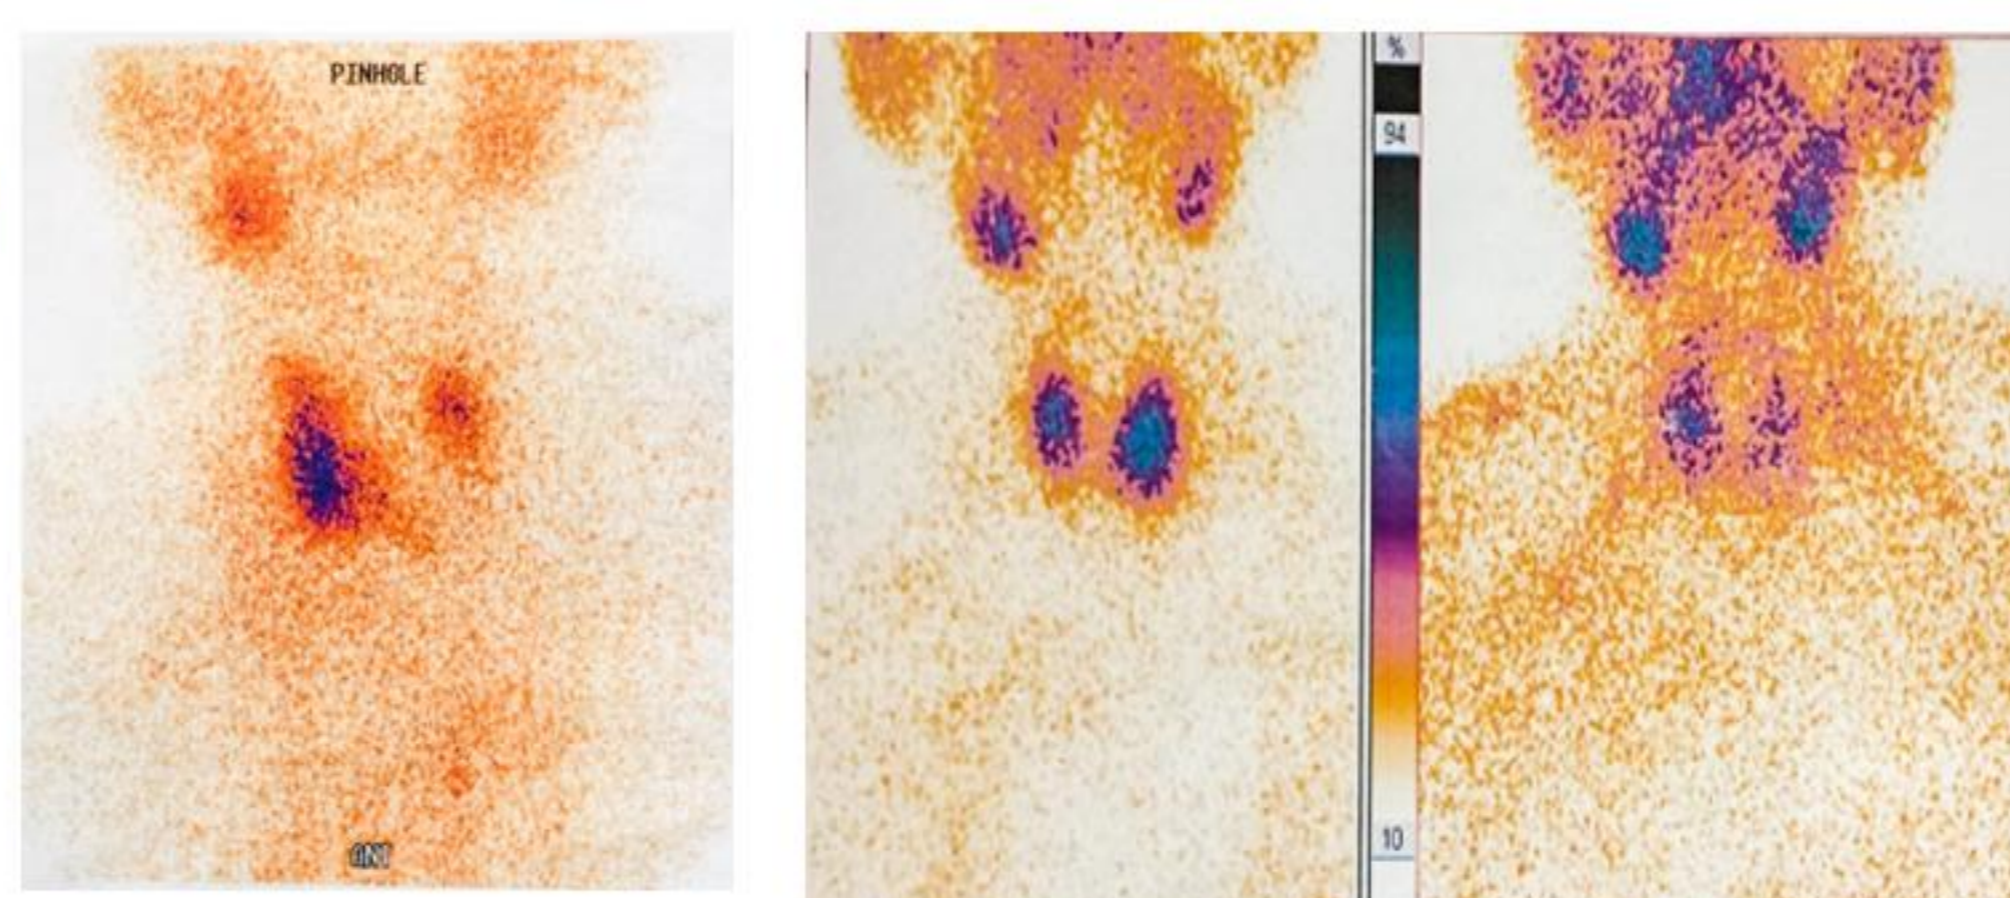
Thyroid scintigraphy.
